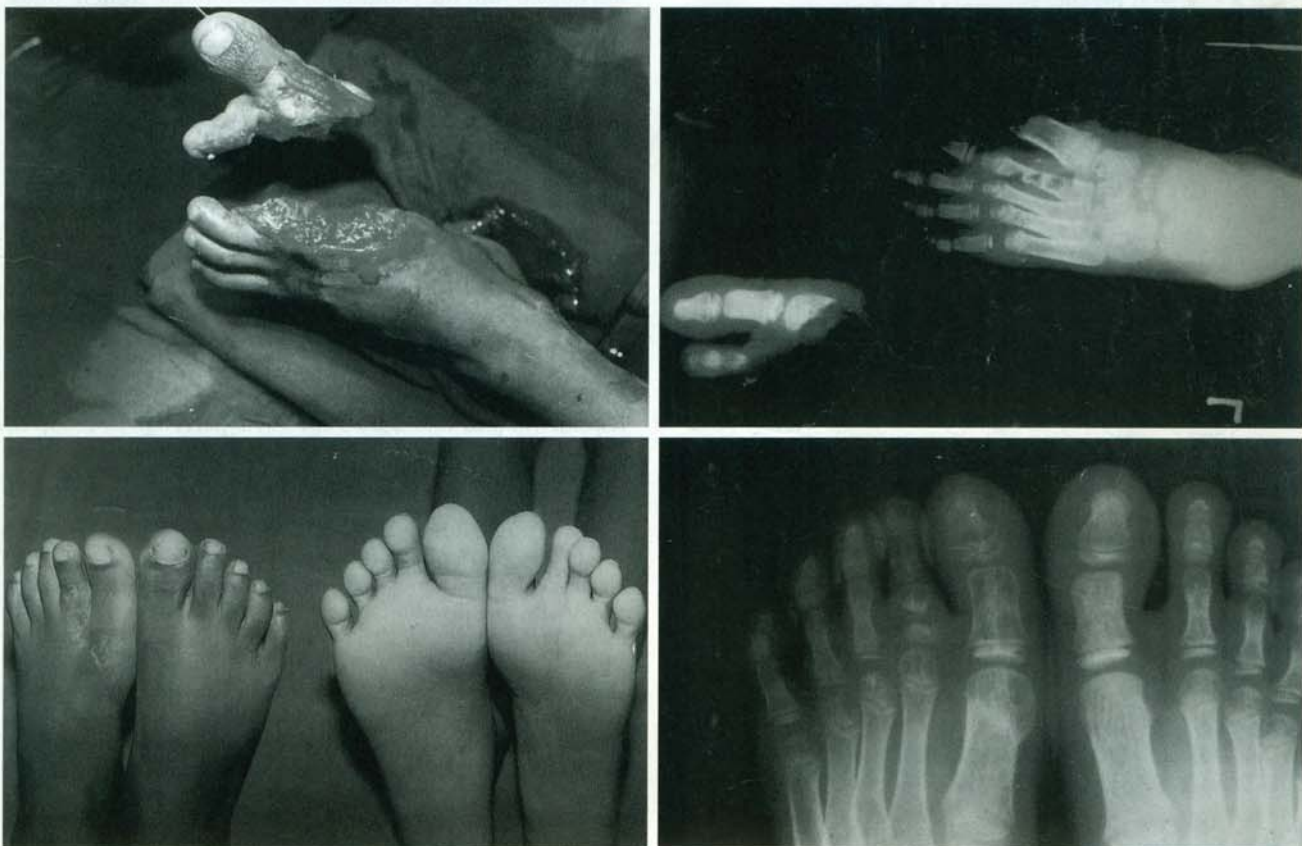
(*Above, left*) Preoperative view showing the amputated great and second toes. (*Above, right*) Preoperative x-ray showing the level of amputation. (*Below, left*) Postoperative dorsal and plantar views at 18-month follow-up. (*Below, right*) Postoperative x-ray showing bony growth at 18 months.
